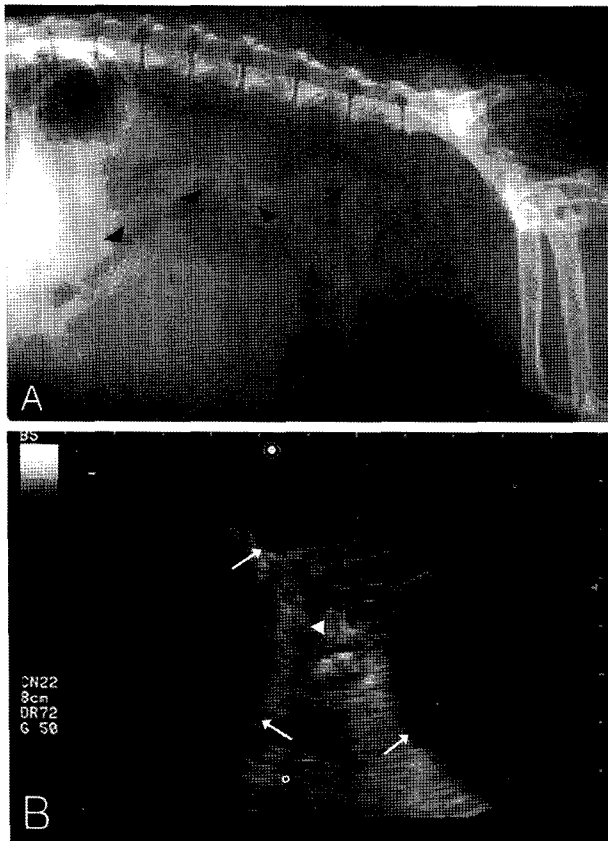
(A) Abdominal radiography revealed a large soft tissue-density mass (arrow heads). (B) Several discrete anechoic follicles (arrows) and irregular masses of heterogeneous echogenicity (arrow head) were found on abdominal ultrasonography.
